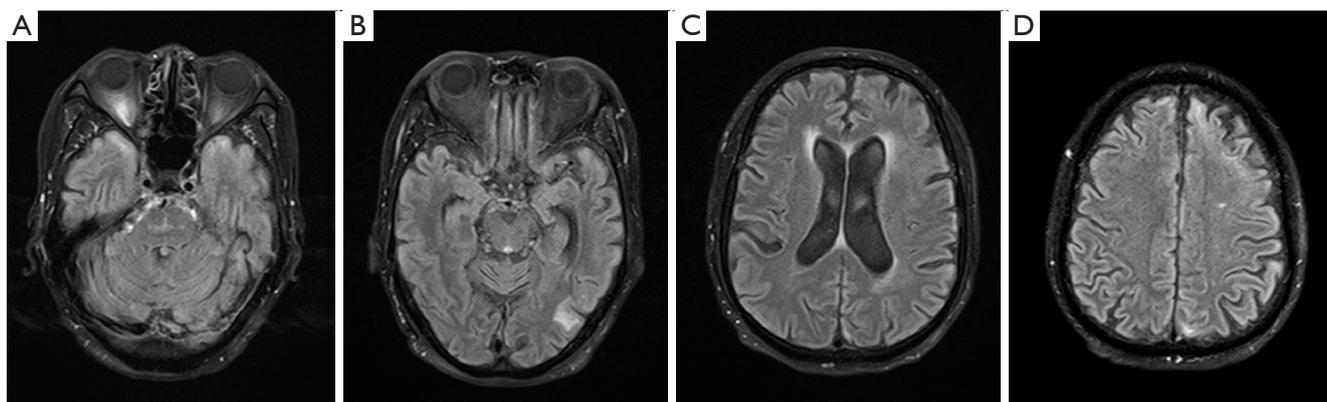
(A-D) Magnetic resonance imaging in February 2022 revealed improvement and recovery according to fluid-attenuated inversion recovery.
